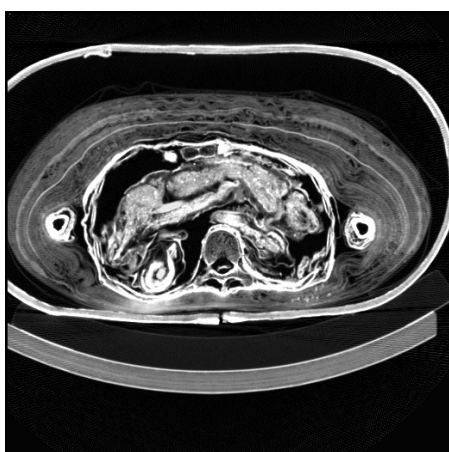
CT through the abdomen showing the organ packs. In the 21<sup>st</sup> dynasty, the lungs, stomach, liver and intestines were taken out, mummified, and put back into the chest and abdomen. Note the horseshoe shaped structure on the lower left which appears to be enclosing a smaller object
